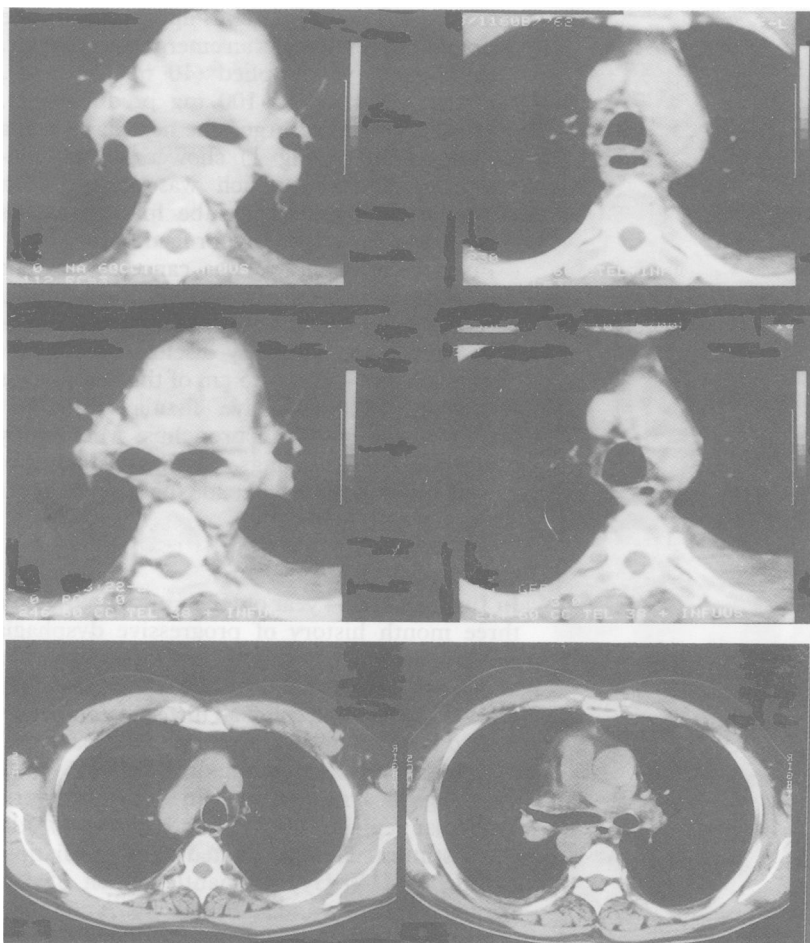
Case 2 (Hodgkin's disease): Computed tomography scan of the mediastinum. Top: at presentation showing a circular oesophageal tumour, possibly invading the aortic arch, no pathological lymph nodes. Middle: after 8×MOPP showing only slight residual thickening of the oesophageal wall at the level of the carina. Bottom: showing normal appearance of the oesophagus four years after diagnosis. MOPP=mitoxine, vincristine, procarbazine, prednisolone.
